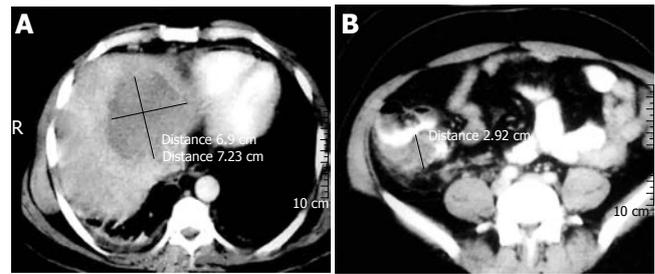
Contrast-enhanced CT scan of the abdomen with the presence of ALA in the liver (A) and ileocecal mass (B).
